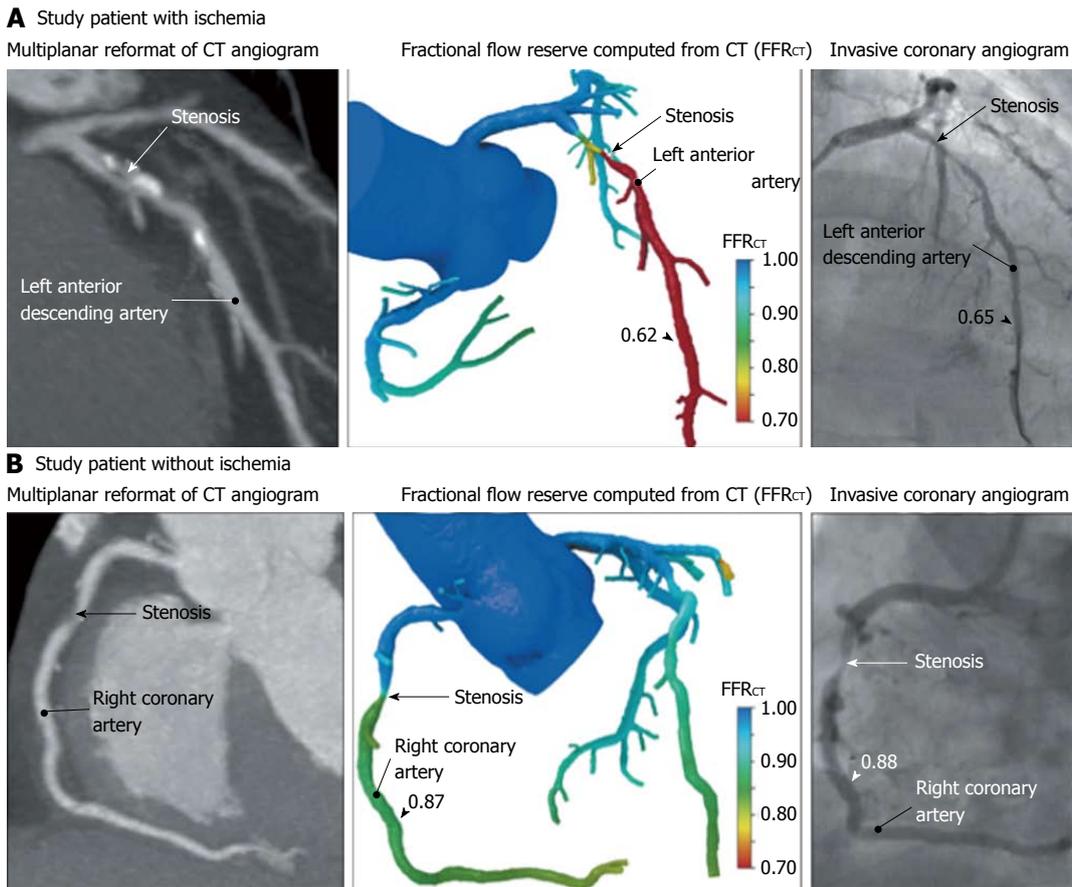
One patient (A) has ischemia and the other patient (B) does not have ischemia^[49]. A: Multiplanar reformat of a computed tomography (CT) angiogram demonstrating obstructive stenosis of the proximal portion of the left anterior descending artery (LAD) and a computed fractional flow reserve (FFR_{CT}) value of 0.62, indicating vessel ischemia. Invasive coronary angiogram demonstrates obstructive stenosis of the proximal portion of the LAD and measured fractional flow reserve (FFR) values of 0.65, indicating vessel ischemia; B: CT angiogram demonstrating obstructive stenosis of the mid portion of the right coronary artery (RCA) and an FFR_{CT} value of 0.87, indicating no vessel ischemia. Invasive coronary angiogram demonstrates obstructive stenosis of the mid portion of the RCA and a measured FFR value of 0.88, indicating no vessel ischemia.
